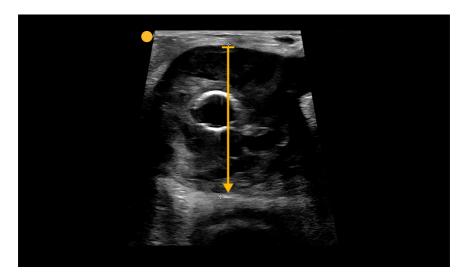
Aneurysms can be identified on ultrasound by comparison or direct measurement. With the comparison method, a bulge is considered an aneurysm if it is 1.5 times greater in diameter than the proximal segment. With direct measurement, a bulge is considered an aneurysm if it is greater than or equal to 10 mm in the popliteal artery or 15 mm in the common femoral artery.
